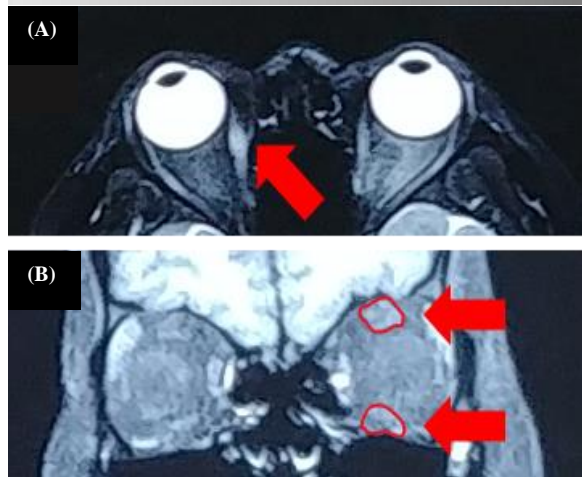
Orbital MRI with axial view (A) and coronal view (B) showed thickening of right ocular medial rectus muscle belly (red arrow) and left superior and inferior rectus muscle (red arrow and circle), without tendinous insertion involvement.
